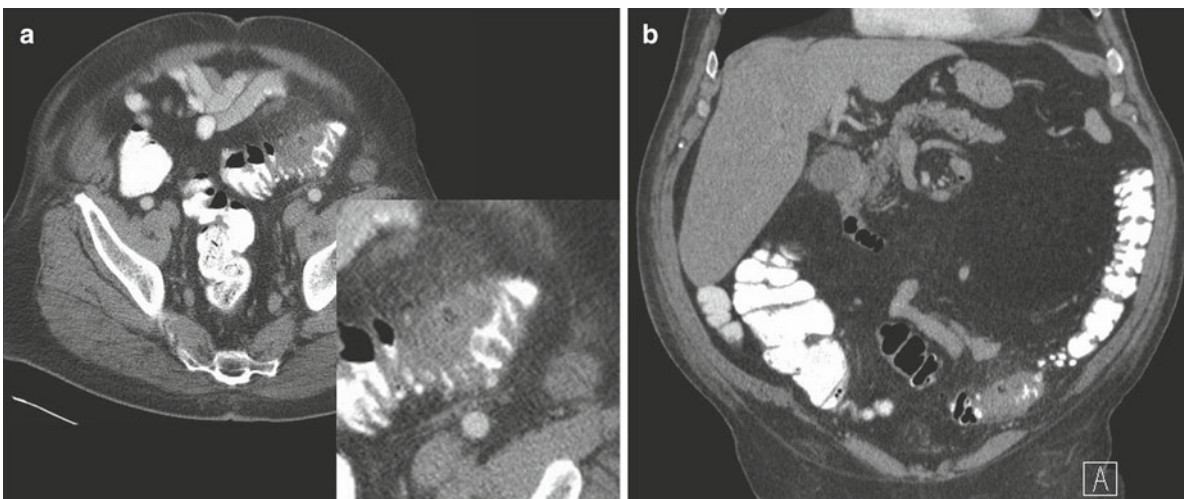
An 83-year-old man with fever, leukocytosis, left lower quadrant (LLQ) abdominal pain, and tenderness. (a) Axial oral and intravenous contrast enhanced CT image through the mid pelvis with enlargement (inset) shows abnormal sigmoid colon with multiple diverticula.
